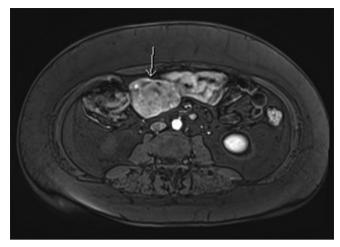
Magnetic resonance imaging of the abdomen and pelvis, a 6.8-cm tumor with heterogenous enhancement in the mesentery, proved to be a metastatic gastrointestinal stromal tumor
